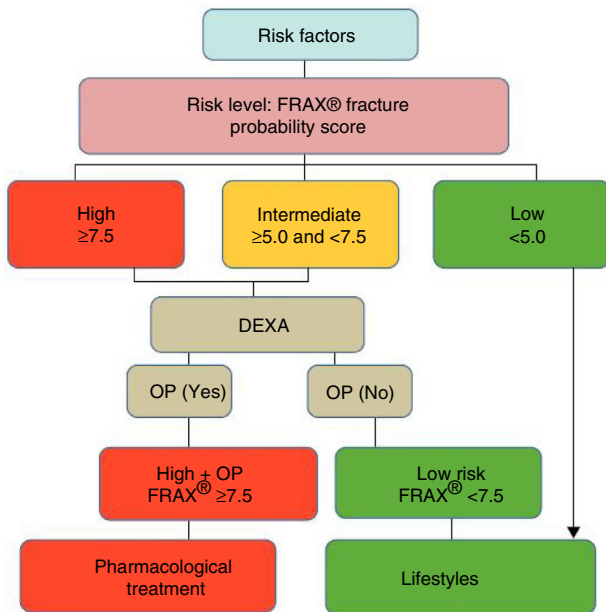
Decision tree based on the most cost-effective option in the Spanish FRIDEX cohort of Spanish women (general population) who did not receive treatment during the 10 years of follow-up.⁴⁷ DEXA or DEXA: Dual-Energy X-ray absorptiometry; OP: osteoporosis.
